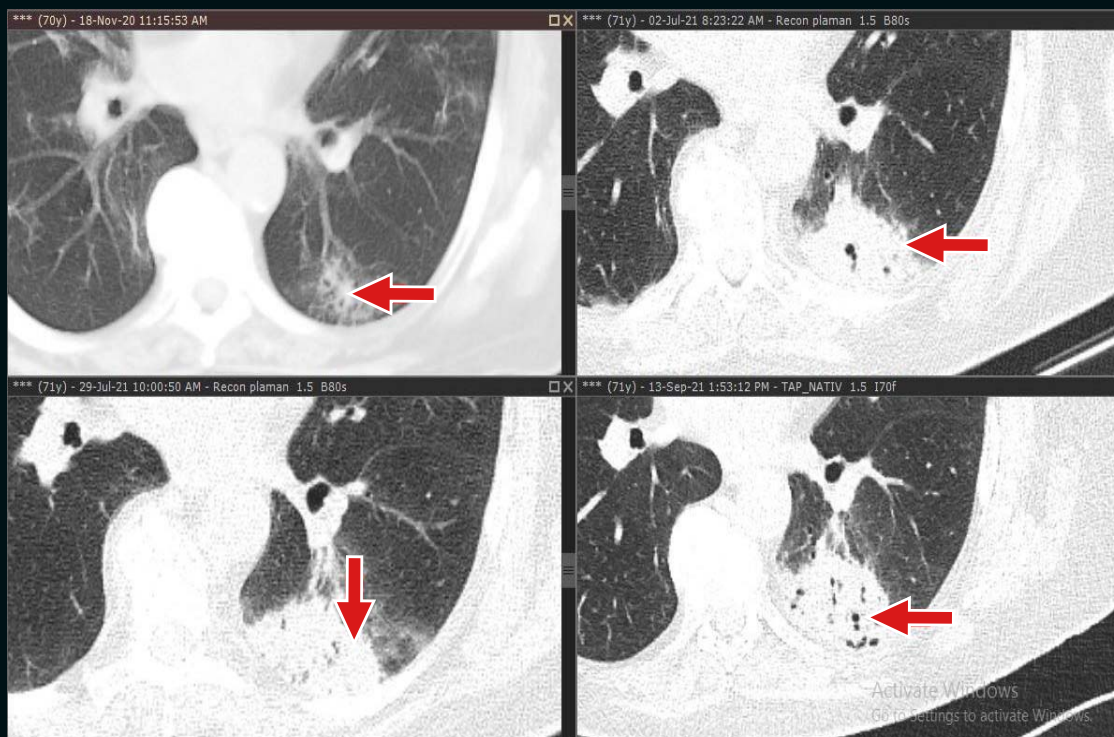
CT scan evaluations (axial section) throughout the year have shown the progression of alveolar consolidation with air bronchogram in the left Fowler segment, with specific changes in its dimensions (red arrow)
